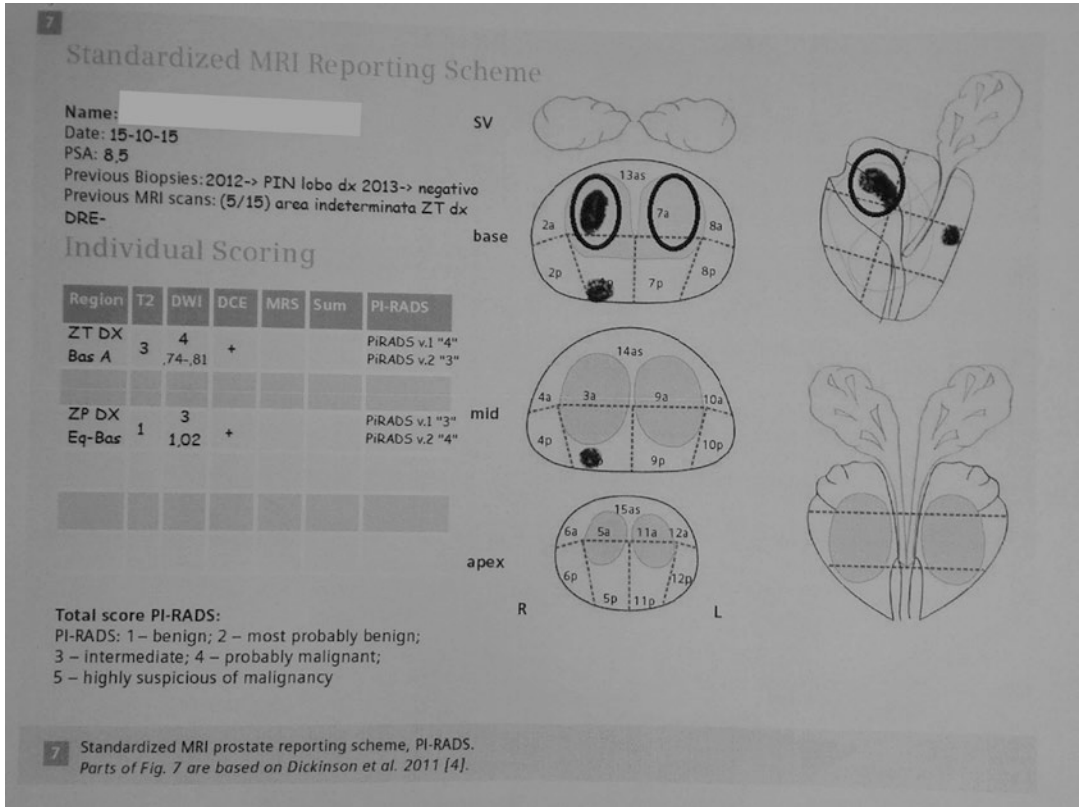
mp-MRI report scheduling all the suspicious lesions classified by PI-RADS score
